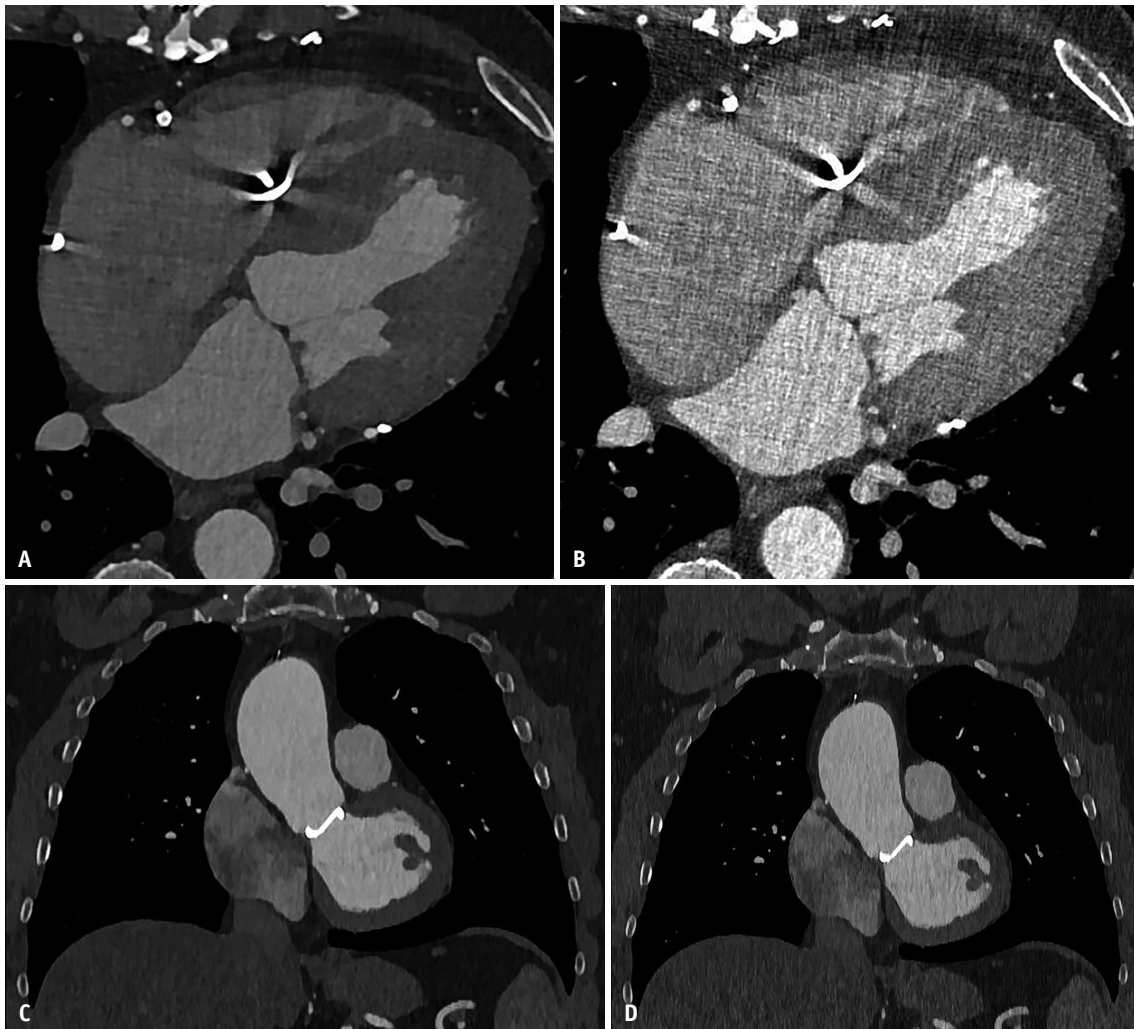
Challenges of PCCT. A: Axial coronary CTA from PCCT in a 61-year-old male using Bv48 filter shows good image quality. B: Axial coronary CTA in the same patient using sharper Bv60 filter shows increased noise. Noise is a key limitation of ultra-high-resolution images, especially with thin slices, sharp kernels, and high matrix size. C: Coronal CTA from PCCT in a 45-year-old male using Bv44 filter shows artificially “painted” margins. D: Coronal CTA in the same patient using sharper Bv56 filter shows improved, more natural image appearance. PCCT = photon-counting CT, CTA = CT angiography
